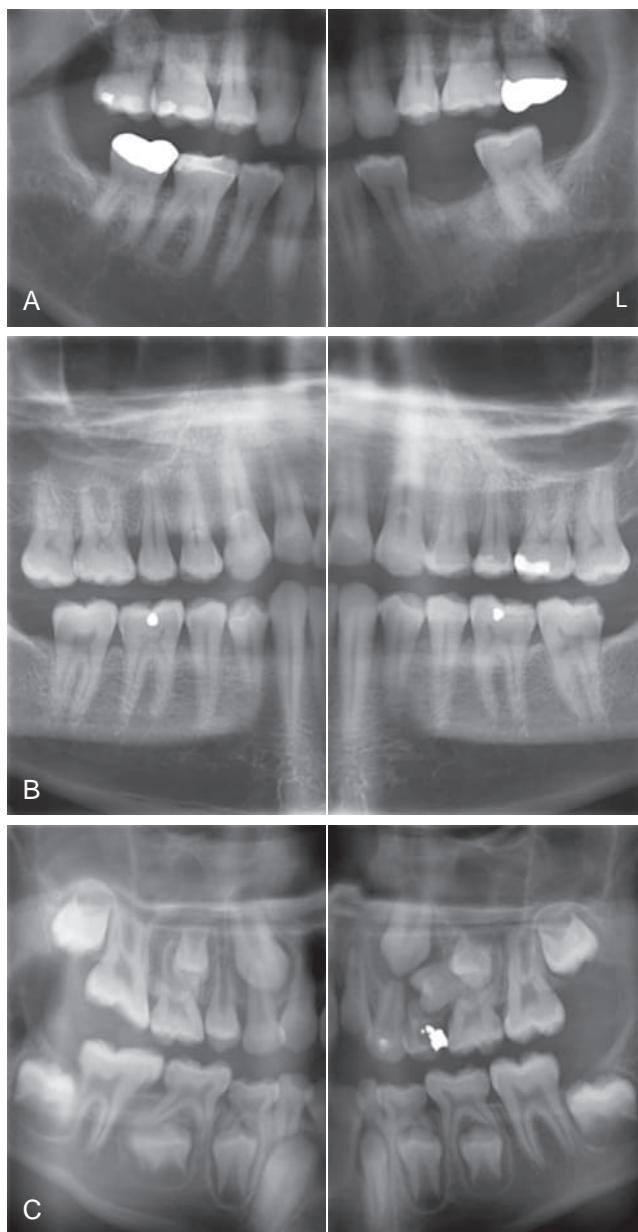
Examples of bitewing radiographs taken with a panoramic machine (A) Planmeca ProOne; (B) Planmeca S2 Pan; (C) Planmeca S3 Promax.
